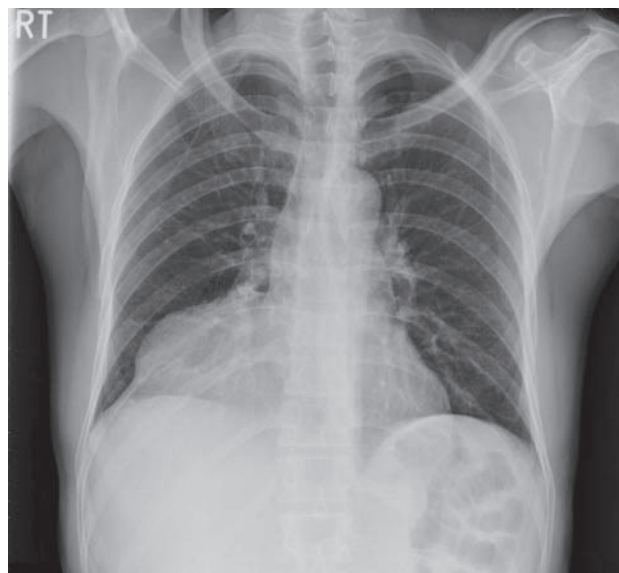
Chest radiograph showing an abnormal mass in the right lower hemithorax.
